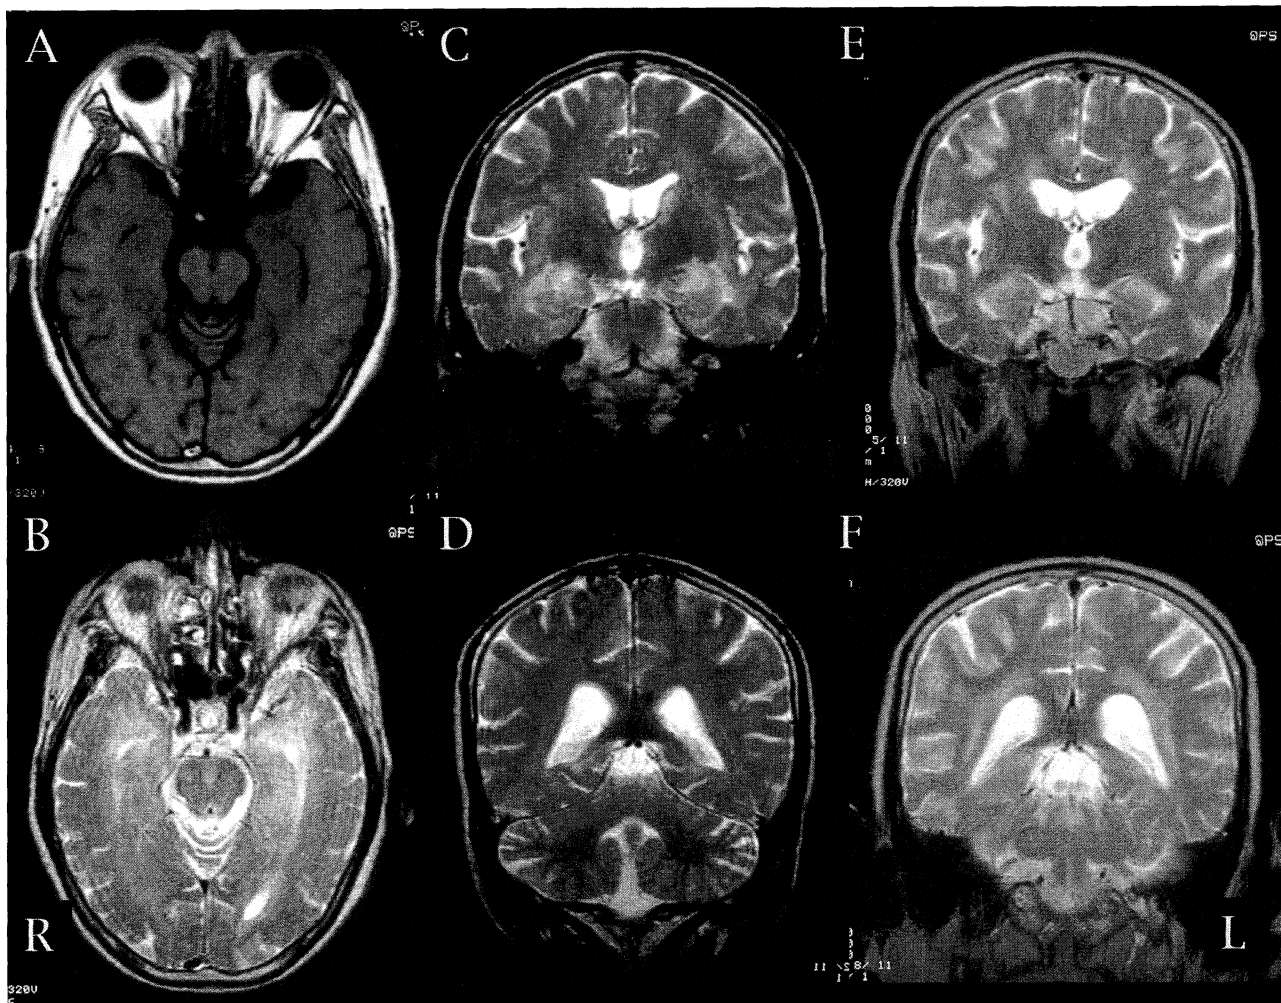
MR images. A, B, C, and D were taken on April 27 1997; E and F were taken on May 29 1997. A: axial T1WI; B: axial T2WI; C: coronal T2WI at the anterior horn level; D: coronal T2WI at the middle portion of lateral ventricles; E: coronal T2WI at the anterior horn level; F: coronal T2WI at the middle portion of lateral ventricles. MR images showed abnormal signal loci (low signal in T1WI and high signal in T2WI) in bilateral amygdala and hippocampus (A, B, C, and E). These lesions revealed no enhancement with gadolinium (data not shown). Moderate cerebral atrophy with periventricular high-signal area in T2WI became evident in later series of MR images (E and F).
